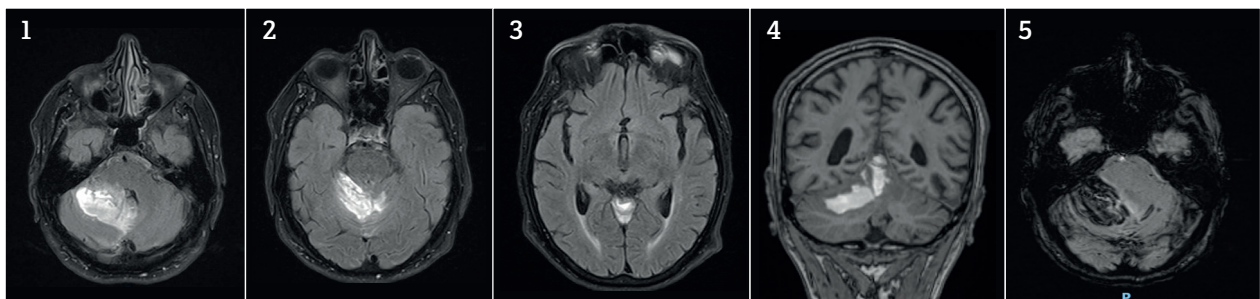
Brain MRI (1,2,3: Axial Flair, 4: Coronal T1, 5: SWI): Corticosubcortical hemorrhage in the right cerebellar hemisphere with extension to the right medial cerebellar peduncle and superior portion of vermis.
